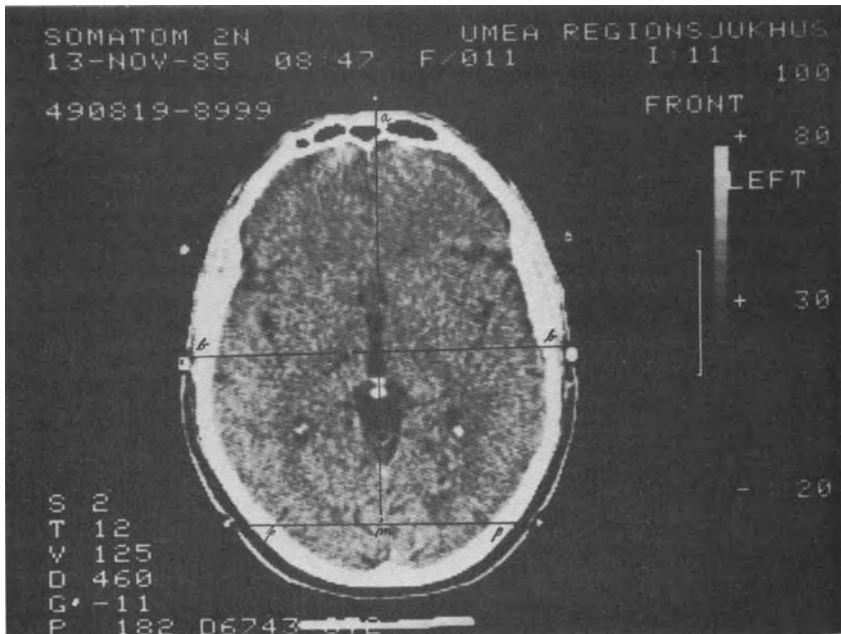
Postoperative CT study confirms the final size and the site of the lesion as well as the reproducibility of remounting the adapter. The arrow points to a spherical lesion in the ventrolateral nucleus of the thalamus, close to the internal capsule.
